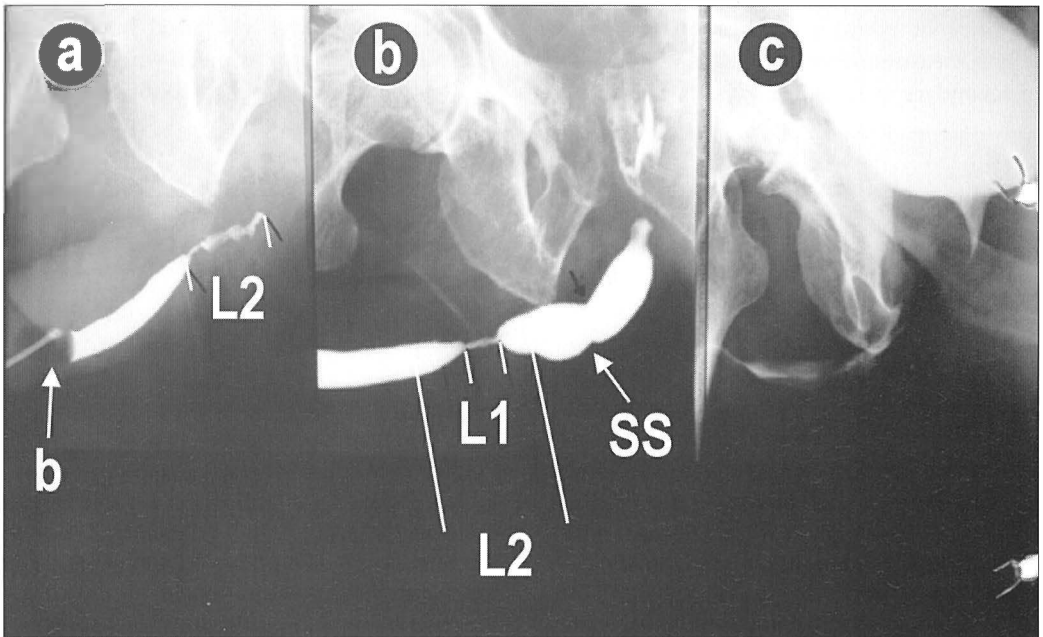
Radiographic urethrography(RUG); a) Less contrast application, b)More contrast application. L2-the length of the whole stricture, L1-the length of a tight stricture, SS- secondary soft stricture, b-baloon of the urethral catheter.
